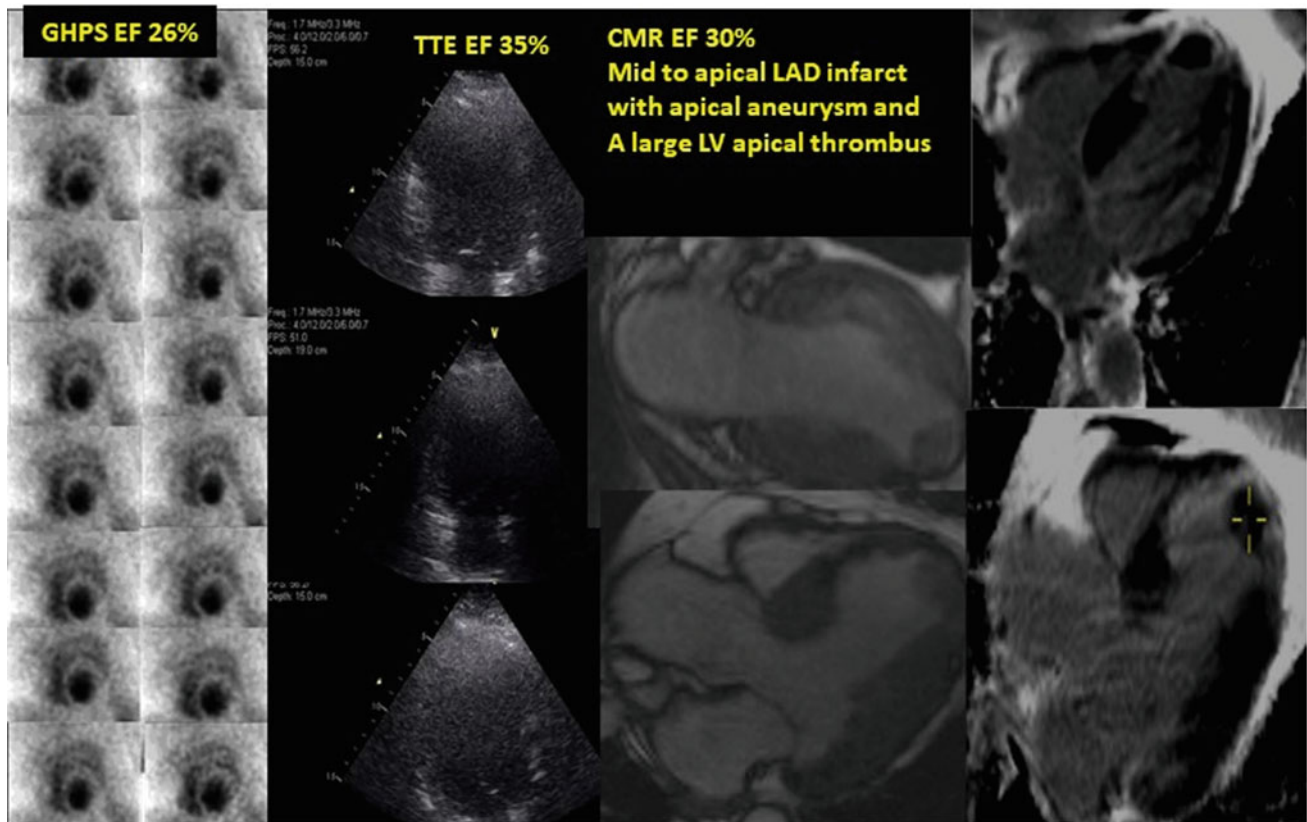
Multi-modality imaging and additional findings using CMR. Left panel gated heart pool scan (GHPS) with EF of 26%. Next panel, transthoracic echocardiogram (TTE) with technically poor images particularly at the apex, EF 35%. Next panels cardiac magnetic
